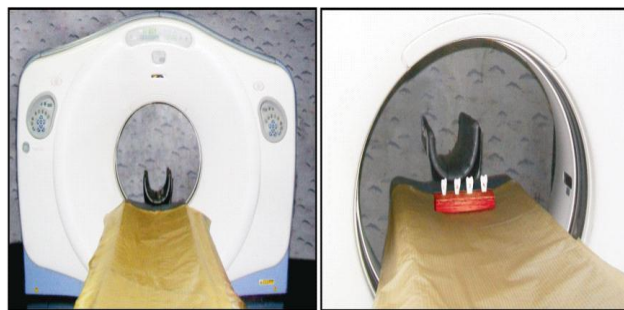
Teeth subjected to high quality computed Tomography (G.E. Light Speed Pro) Scanner.
